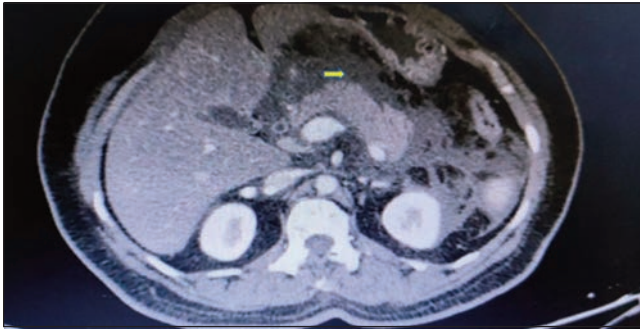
CT scan of patient showing pancreatic oedema, peri-pancreatic fluid collection.
